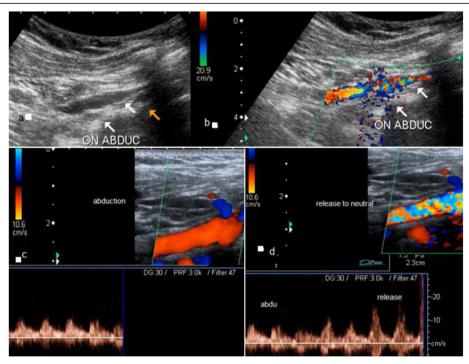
a B-mode image of the axillary-subclavian artery junction showing tapered significant narrowing of the axillary artery on arm abduction (white arrows) at the outlet of the costo-clavicular space (yellow arrow). b Color image for the same arterial segment in (a) showing marked color aliasing with a visible bruit due to high velocity jet of the arterial stenosis (white arrows). c Spectral and color Doppler image for the downstream brachial artery showing significant dampening of the flow on arm abduction. d Spectral and color Doppler image showing rebound hyperemia (color aliasing) with increased velocity on release of the impingement of the artery by return to the neutral arm position
